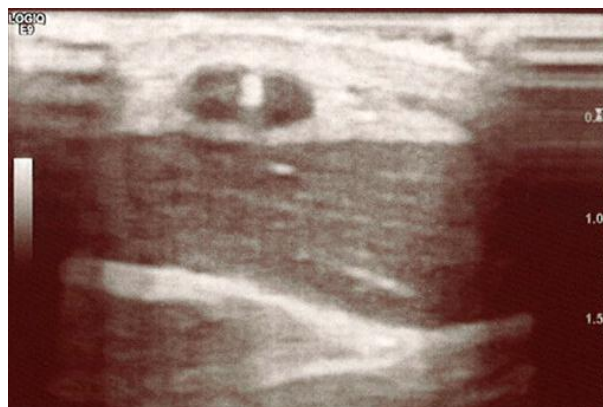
Ultrasonic scan of Subject 021 showing an increasing thrombus formation from proximal to distal.
